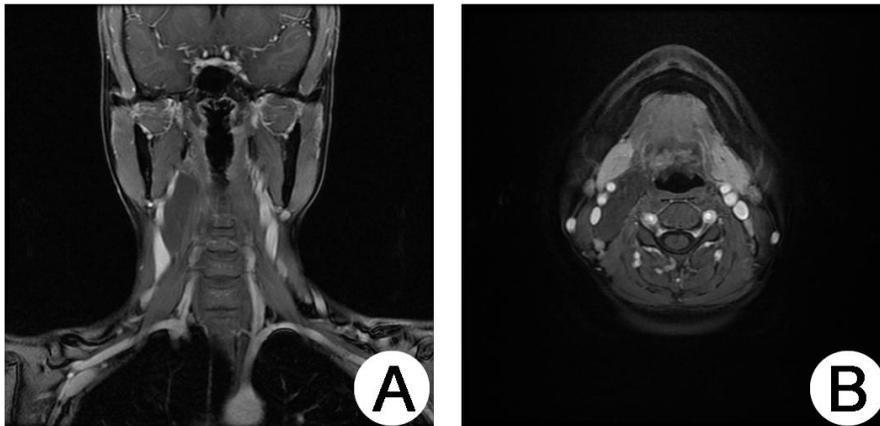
Magnetic resonance imaging showing the isodense lesion which is uniformly enhancing with the surrounding vessels in the parapharyngeal on T1-WI. (A) coronal view; (B) axial view.
